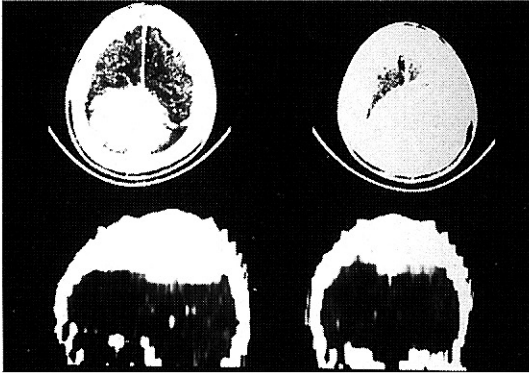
Horizontal CT scans without contrast enhancement shows vertex hyperdensity(upper). Coronal reconstruction from the axial CT scans clearly demonstrates the vertex epidural hematoma(lower).
